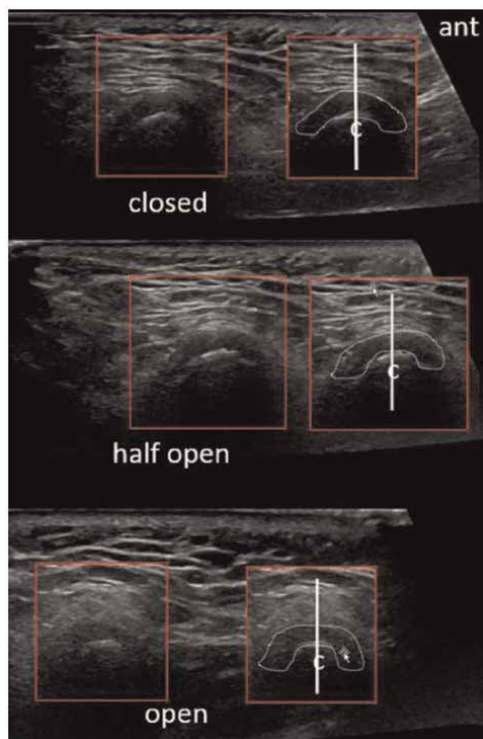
On normal ultrasonography, the articular disc appears in the sagittal plane as an inverted hypoechoic c-shaped structure. Throughout the closed-mouth, half-open-mouth, and fully-open-mouth views, the disc maintains a consistent central appearance in relation to the center of the condyle, “c,” which is delineated by a central vertical line. The articular disc’s anterior (“ant”) and posterior bands appear to be symmetrical in size when viewed from the center of the condyle. A focused annotated view was supplied to help visibility, with the articular disc highlighted with a dotted contour.
